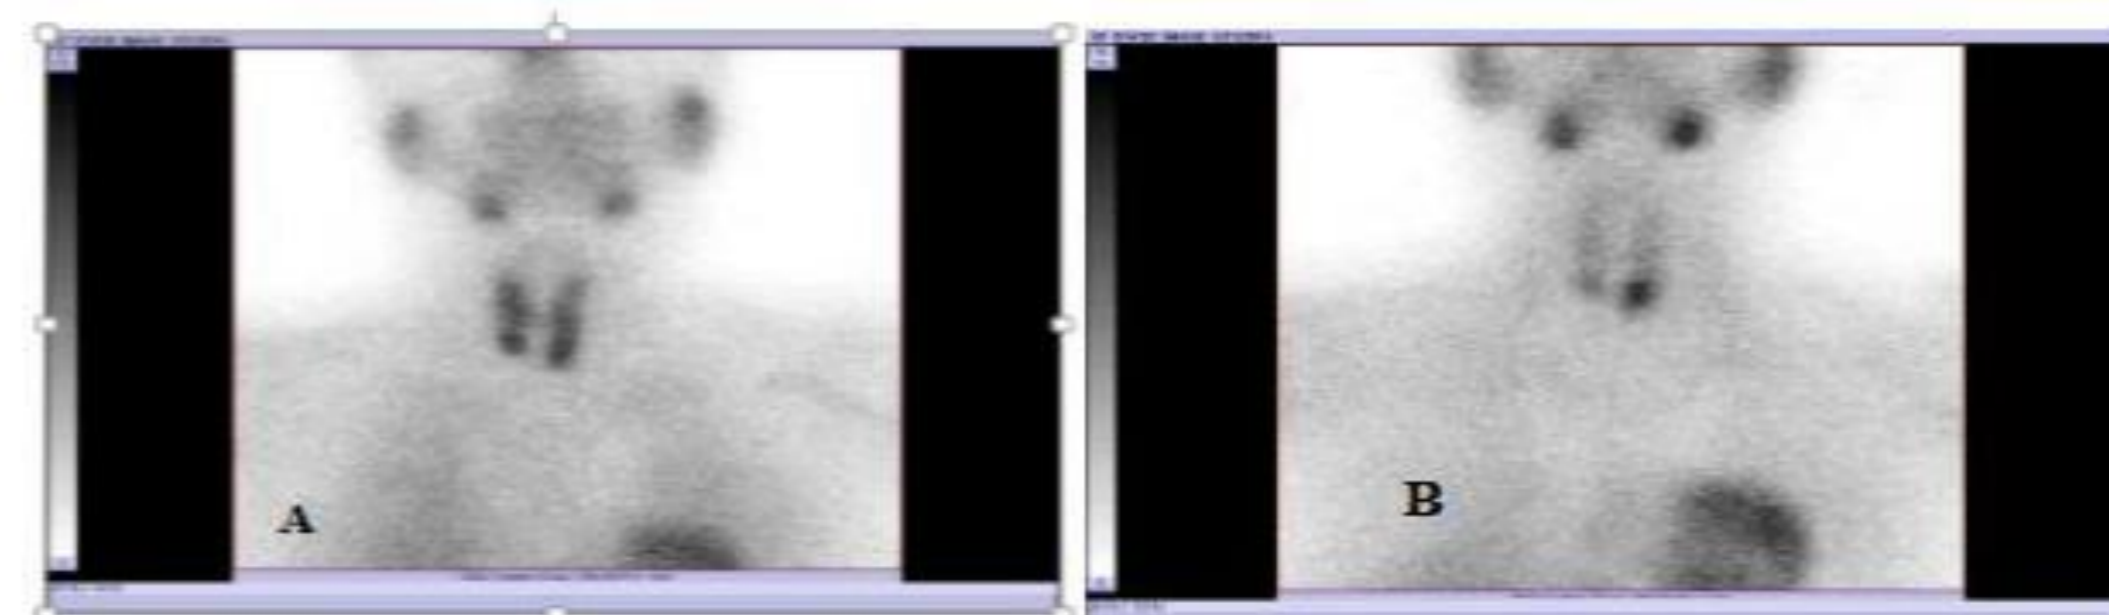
Early phase of parathyroid scintigraphy in A image and late phase of parathyroid scintigraphy in B image
